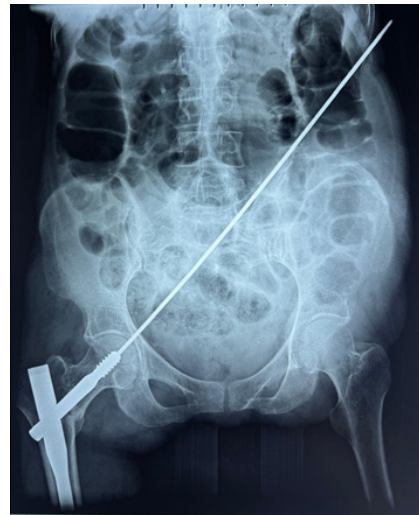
Abdominal radiograph showing intra-abdominal migration of an osteosynthesis pin.
